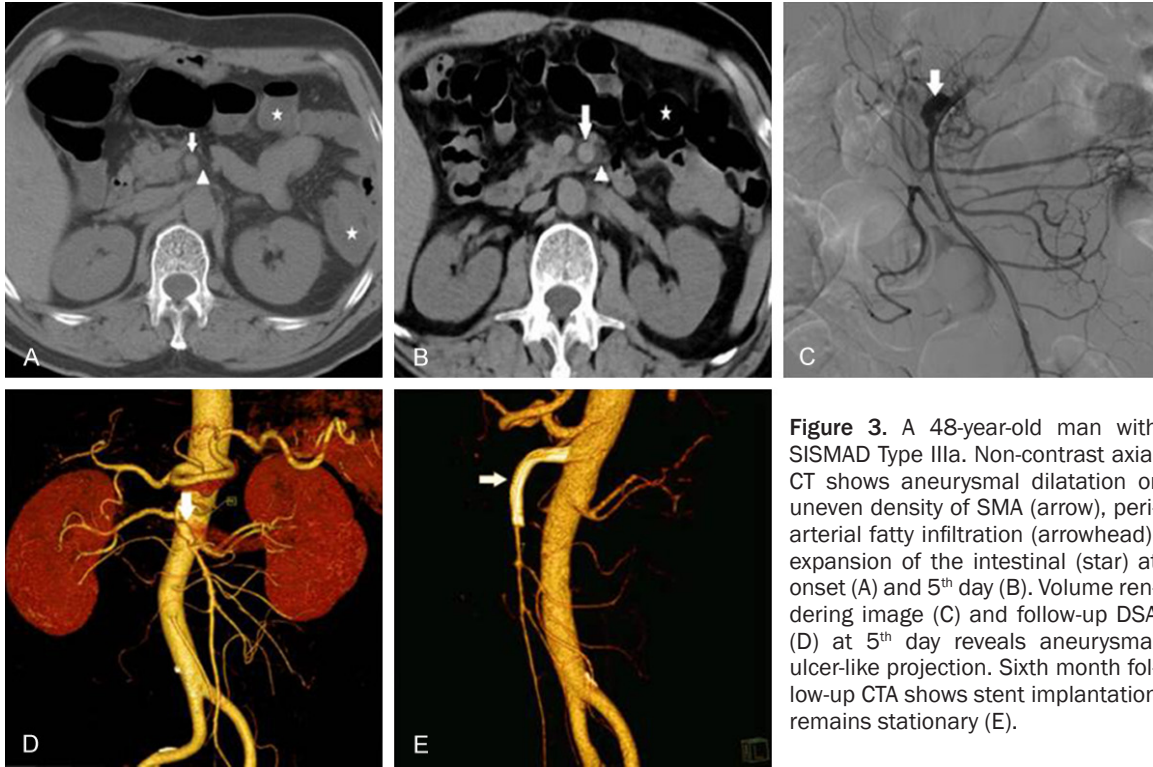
A 48-year-old man with SISMA Type IIIa. Non-contrast axial CT shows aneurysmal dilatation or uneven density of SMA (arrow), periaortic fatty infiltration (arrowhead), expansion of the intestinal (star) at onset (A) and 5th day (B). Volume rendering image (C) and follow-up DSA (D) at 5th day reveals aneurysmal ulcer-like projection. Sixth month follow-up CTA shows stent implantation remains stationary (E).
